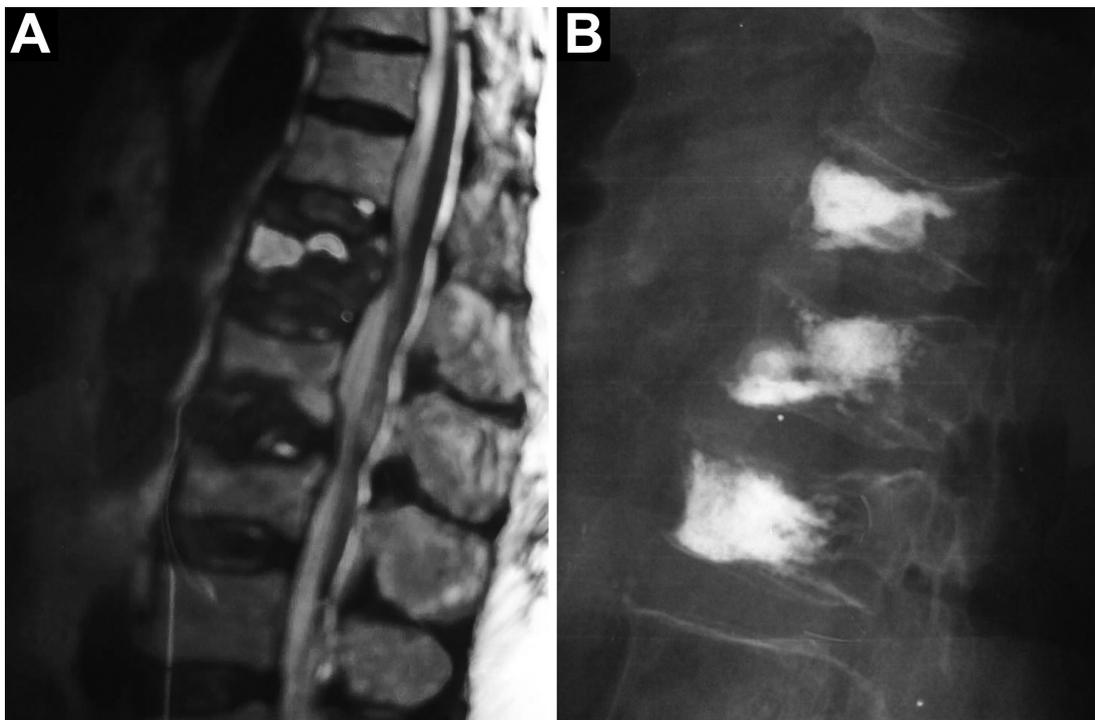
On MRI T2 weigh image (A), the OVFs nonunion is described as a high intensity signal of distinct focal cleft filled with fluid. During kyphoplasty the confinement of the cavity was disrupted with special osteotome in order to allow the cement to interdigitate with the trabeculae (B).
